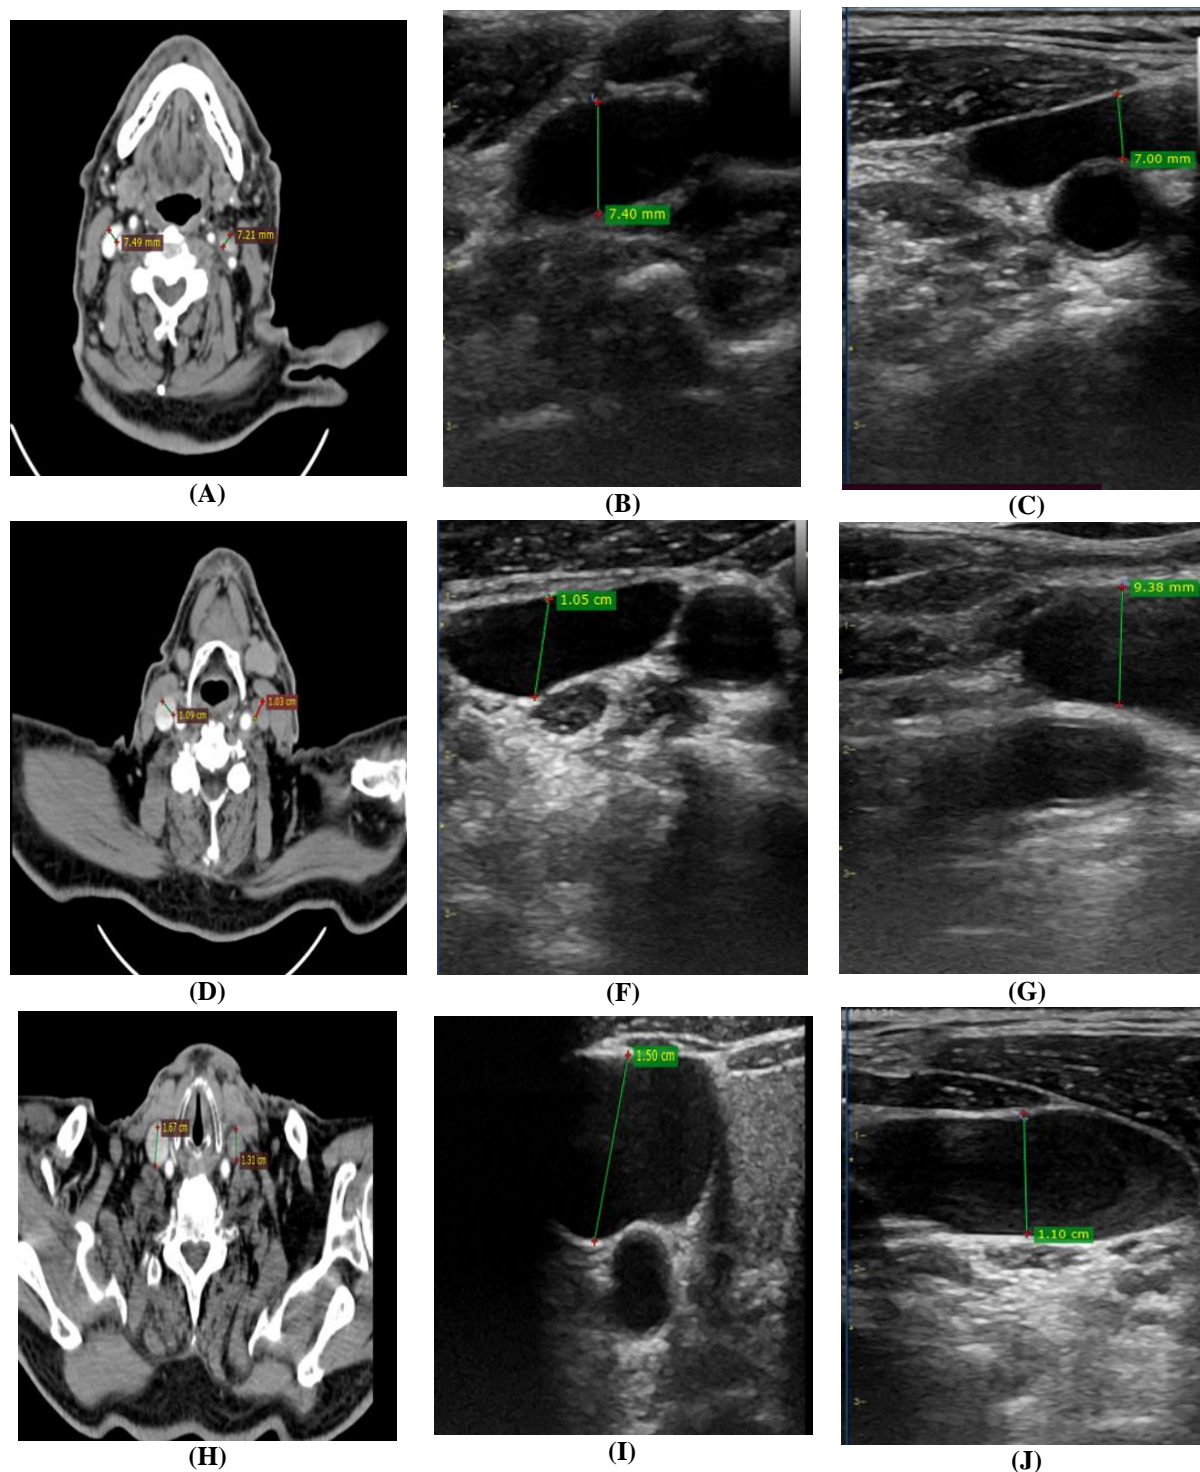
(A) CT neck with IV contrast showing AP diameter of RT IJV which measuring 0.74 cm and AP diameter of Lt IJV which measuring 0.72cm at upper neck,(B) AP diameter of RT IJV by U/S at supine position which measuring 0.74cm at upper neck,(C) AP diameter of LT IJV by U/S at supine position which measuring 0.70cm at upper neck, (D) CT neck with IV contrast showing AP diameter of RT IJV which measuring 1.09 cm and AP diameter of Lt IJV which measuring 1.03cm at middle neck, (E) AP diameter of RT IJV by U/S at supine position which measuring 1.05cm at middle neck, (F) AP diameter of LT IJV by U/S at supine position which measuring 0.93cm at middle neck. (H) CT neck with IV contrast showing AP diameter of RT IJV which measuring 1.67 cm and AP diameter of Lt IJV which measuring 1.31cm at lower neck, (I) AP diameter of RT IJV by U/S at supine position which measuring 1.50cm at lower neck, (J) AP diameter of LT IJV by U/S at supine position which measuring 1.10cm at lower neck
